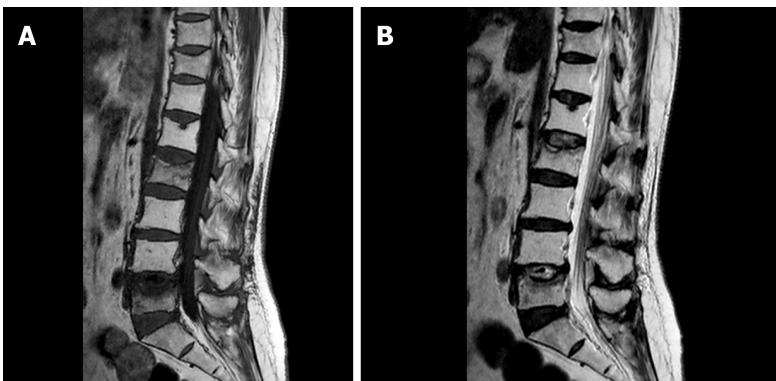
Magnetic resonance imaging. T1-weight (A) and T2-weight (B) image revealed destructive L2 and L5 spine. Related involvement of nearby spinal cord was also noted.
